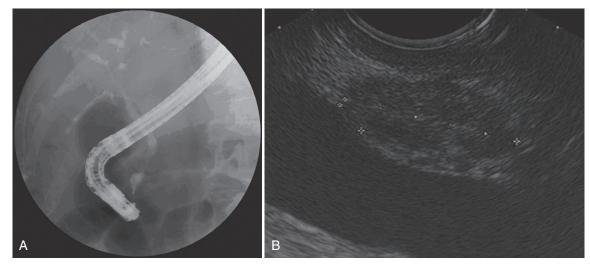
Biliary stricture and pancreas mass due to autoimmune chronic pancreatitis. A and B, Endoscopic retrograde cholangiopancreatography (ERCP) and linear EUS of a 70-year-old Asian man with painless jaundice, mild weight loss, and no past history of alcohol or pancreatitis. A, ERCP shows a tight-shouldered distal biliary stricture, but results of cytologic examination from biliary brushings were negative. Intrahepatic irregularities are also noted. Computed tomography scan of the pancreas was normal. B, A 5 × 25 mm hypoechoic mass, distinct from adjacent noninflamed parenchyma, is seen in the head of the pancreas and abutting the portal vein with a short loss of the interface (*curved bracket*). The rest of the pancreas appeared normal (no chronic pancreatitis criteria). Fine-needle aspiration showed benign cells without plasma cells. A serum immunoglobulin G₄ test was not requested, and surgical pathologic findings were consistent with focal chronic pancreatitis of the head, likely autoimmune.
